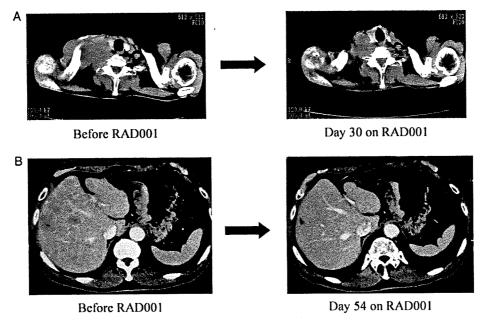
Computed tomography images of tumor response to RAD001 treatment. (A) Shrinkage of metastases in supraclavicular lymph nodes in a patient with esophageal cancer. (B) Shrinkage of liver metastases in a patient with gastric cancer.
